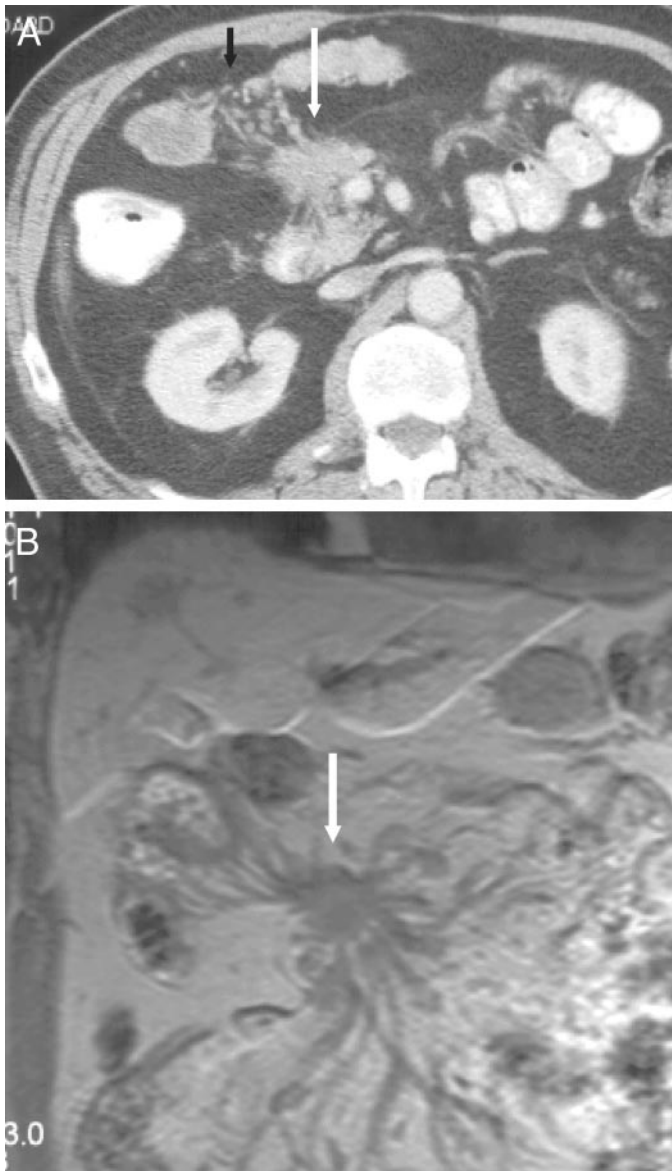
CT (A) and MRI (B) scans of a metastatic NET arising from the midgut, demonstrating an extensive desmoplastic response binding the mesentery (*white arrows*). (Courtesy of Dr. A. G. Rockall and Dr. R. Reznick, Department of Radiology, St. Bartholomew's Hospital, London, UK.)
